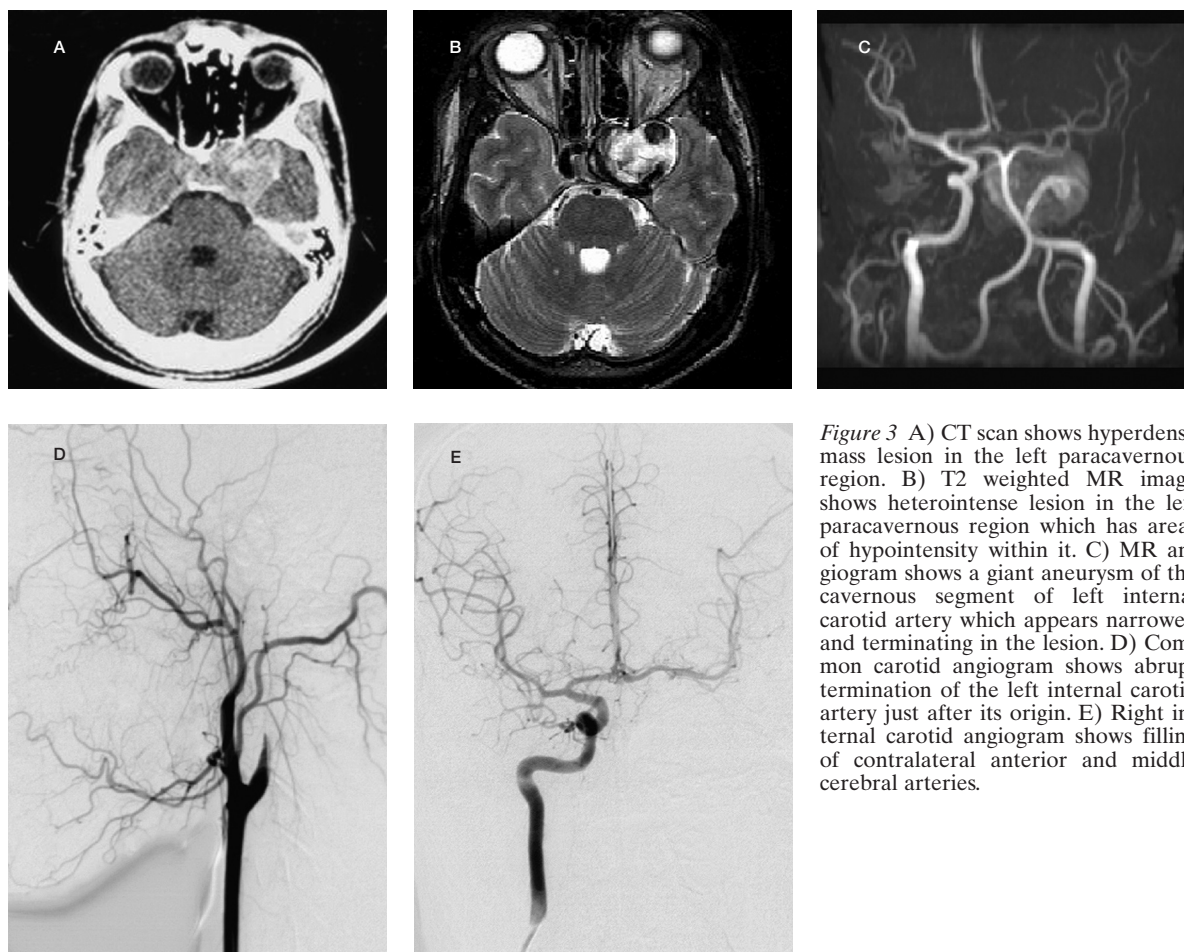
A) CT scan shows hyperdense mass lesion in the left paracavernous region. B) T2 weighted MR image shows heterointense lesion in the left paracavernous region which has areas of hypointensity within it. C) MR angiogram shows a giant aneurysm of the cavernous segment of left internal carotid artery which appears narrowed and terminating in the lesion. D) Common carotid angiogram shows abrupt termination of the left internal carotid artery just after its origin. E) Right internal carotid angiogram shows filling of contralateral anterior and middle cerebral arteries.
